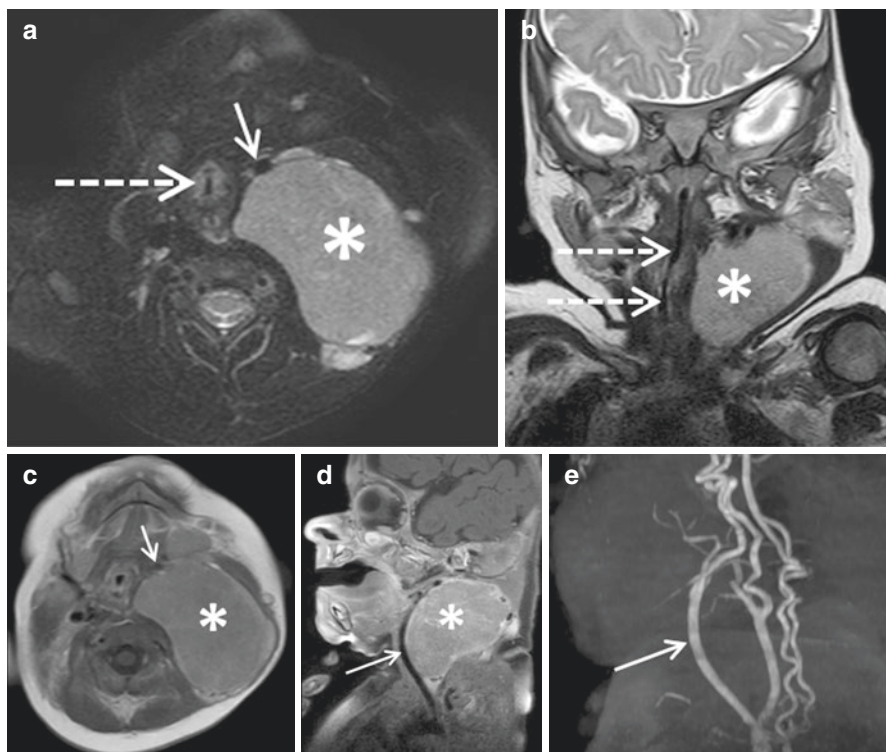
A 5-month-old boy with nonsymptomatic localized left cervical neuroblastoma. MR transverse fat-saturated T2 (a) and coronal (b) T2-weighted sequences, enhanced transverse (c) and sagittal fat-saturated T1-weighted (d) sequences, and lateral MIP reconstruction of contrast-enhanced MR angiography. The tumor (asterisks) arises from the left posterior carotid space and displaces anteriorly the internal carotid artery (arrows), without encasement (not IDRf), and laterally the airways (dotted arrows) but without reduction of the laryngotracheal lumen (not IDRf)
